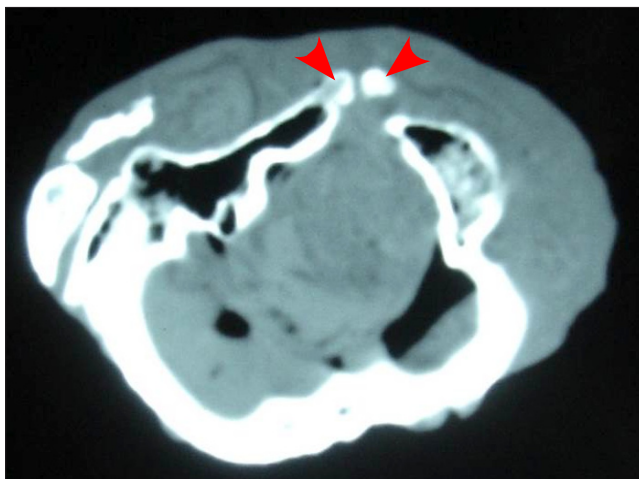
Axial CT slice at the base of a dried skull (same as in Figure 1c) with well-developed bilateral *precondylar tubercles* (arrowheads). Note the shadow of the encapsulating paraffin wax that was used to minimize the bone/air artifact.
